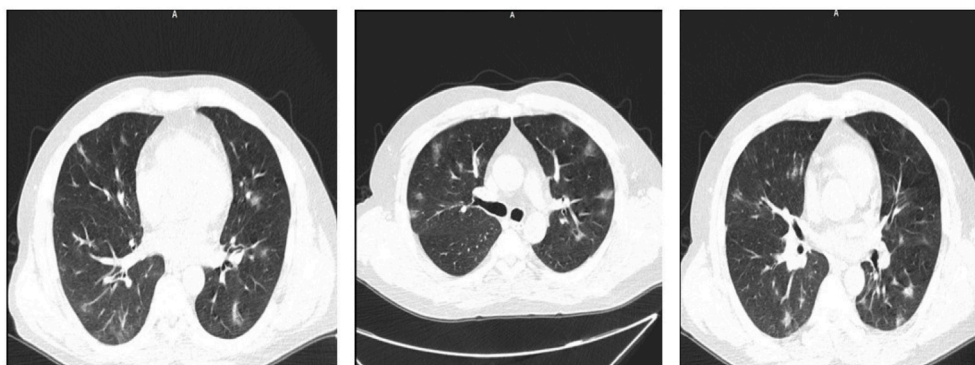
The findings of the patient's pulmonary CT scans.
